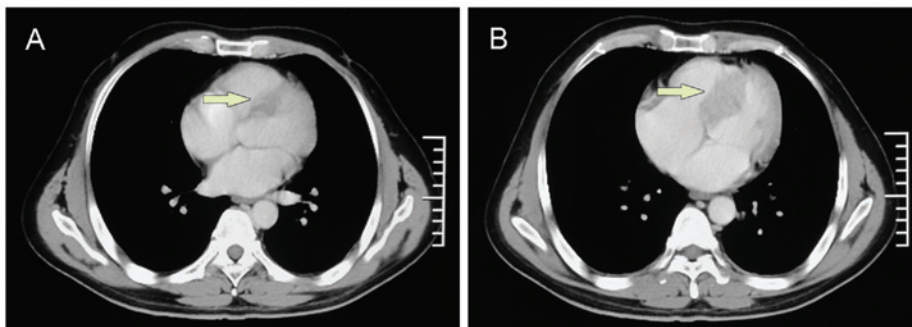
Computed tomography images revealing a 4.0-cm cardiac mass (arrows) in the (A) upper segment extending to the (B) middle of the interventricular septum.
